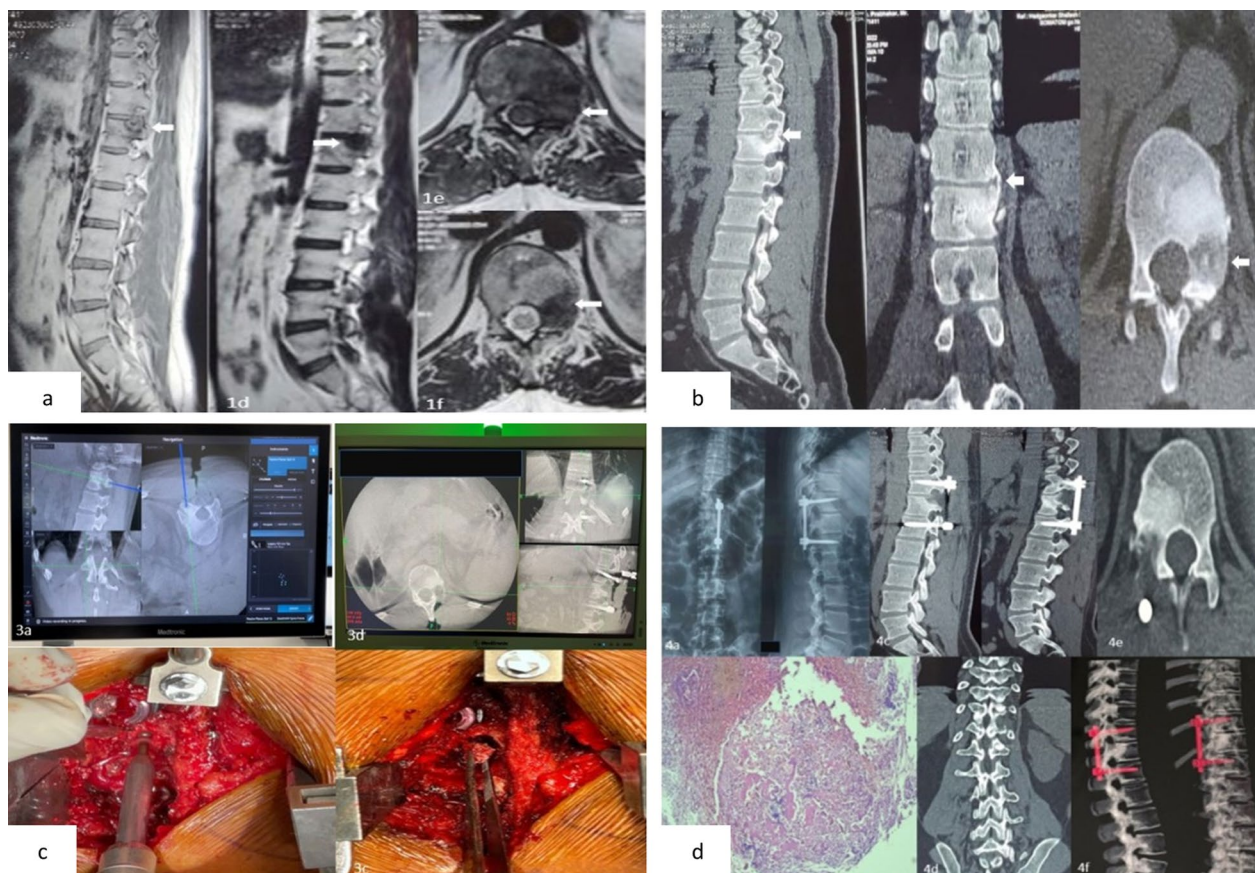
Case 3 a MRI images, sagittal and axial T1w and T2w cuts showing hypointense lesion surrounded by isointense shadow (white arrows); b CT images, sagittal image showing floating foramen nidus, coronal image showing peridiscal osteophyte, axial image showing thinned out ballooned cortex (white arrows); c Intra-operative images; navigation guided exact location of nidus, burring superior articular process of D12 and inferior articular process of D11 and following the path and excision of nidus; d Postoperative X-ray and 2 years follow-up CT images showing loss of lytic and sclerotic shadow, absent nidus, no signs of recurrence and HPE image confirming Osteoblastoma
